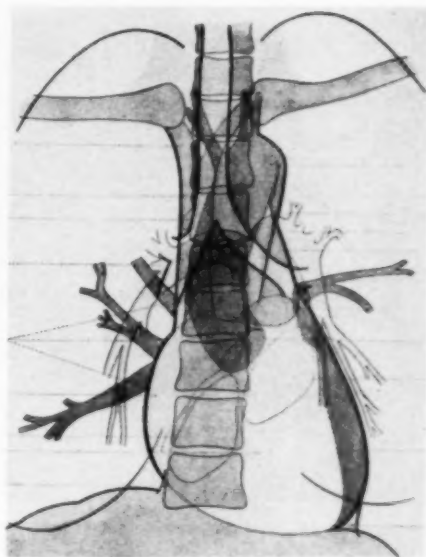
Tracing of a normal chest roentgenogram (from Zdansky). The course of the lower pulmonary arterial branches on the right (lightly shaded) is clearly distinct from the convergent pulmonary veins (darkly shaded).
